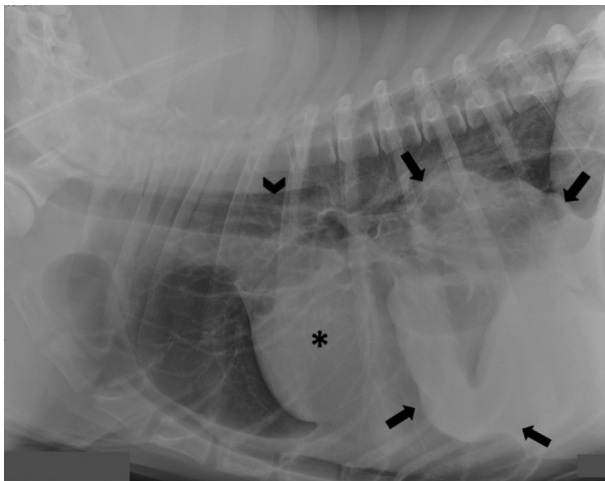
Left lateral thoracic radiograph. There is a soft tissue opacity (arrows) in the caudal to caudoventral aspect of the thorax, causing border effacement of the caudal margin of the cardiac silhouette (asterisk) and the diaphragm. The oesophagus is partially filled with air (arrowhead).
